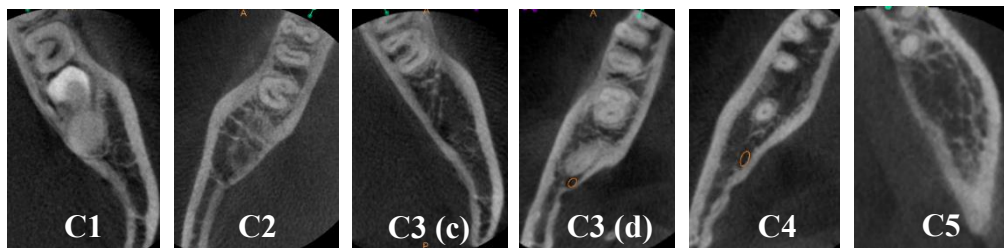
CBCT images of axial slices in which the different categories are shown in accordance with Fan et al. classification.
